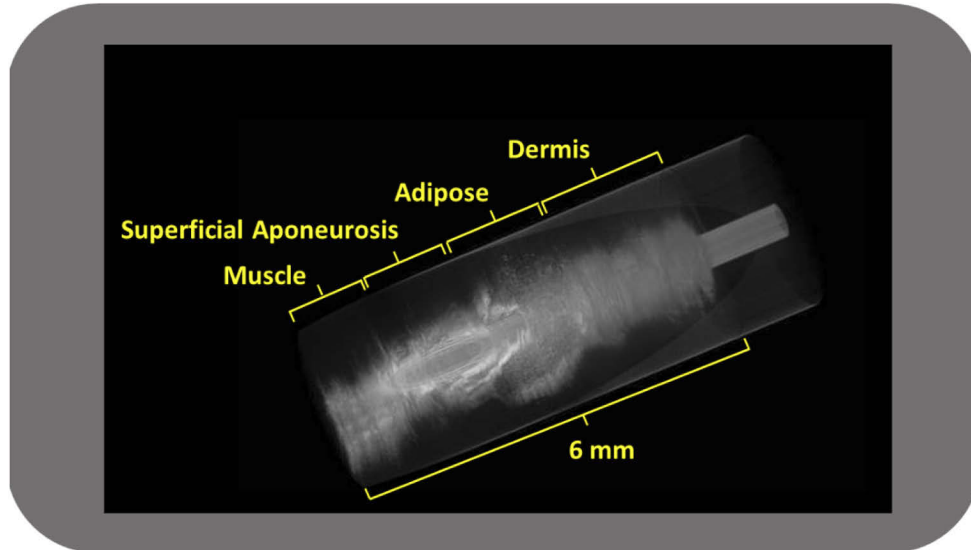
A 3-dimensional image generated by the PS-OCT needle probe scan with corresponding depths of identified tissue as indicated by overlay with ultrasound imaging.
